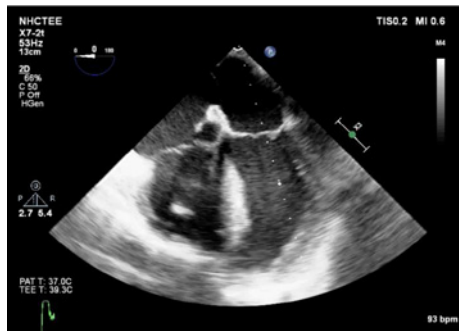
TOE image-apical 4 chamber view.
